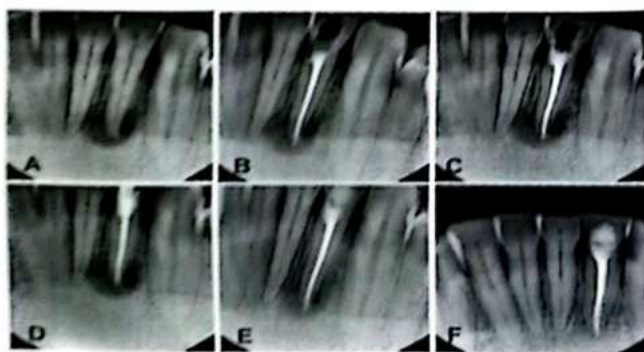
A - F. Root canal treatment followed by intra-coronal bleaching and follow-up of tooth # 32. A, Preoperative intraoral periapical view showing large circular radiolucency around the apex of tooth # 32; B, Removal of approximately 2 mm Gutta Percha obturating material from the pulp chamber after root canal treatment; C, Placement of approximately 2 mm thick Glass Ionomer cement barrier; D, Placement of bleaching agent and restoration by zinc oxide cement; E, 3-months-follow-up showing bone regeneration and gradual disappearance of the periapical radiolucency; F, 1-year-follow-up revealing complete periapical healing by bone regeneration.
